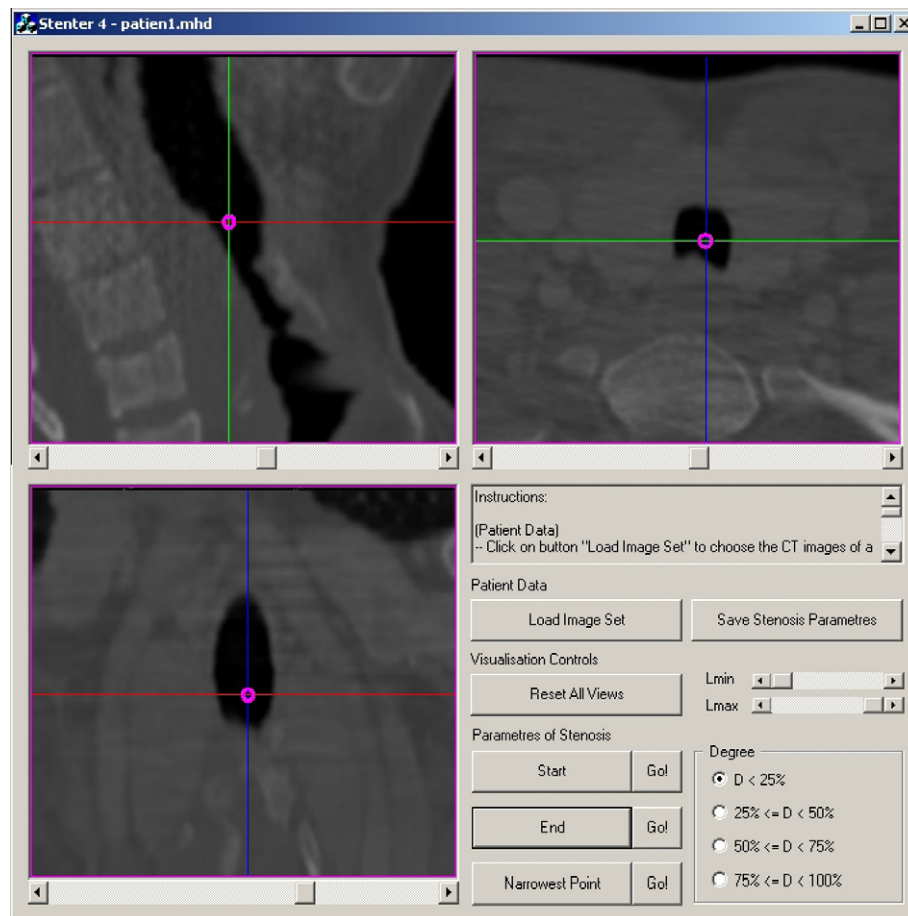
GUI of the application developed for manual/visual assessment of stenosis. The expert marks on the patient's CT image the parameters of the stenosis (start, end, point of maximum degree) and chooses the degree of narrowing from ranges of values. Zooming and panning enhances the visualization.
